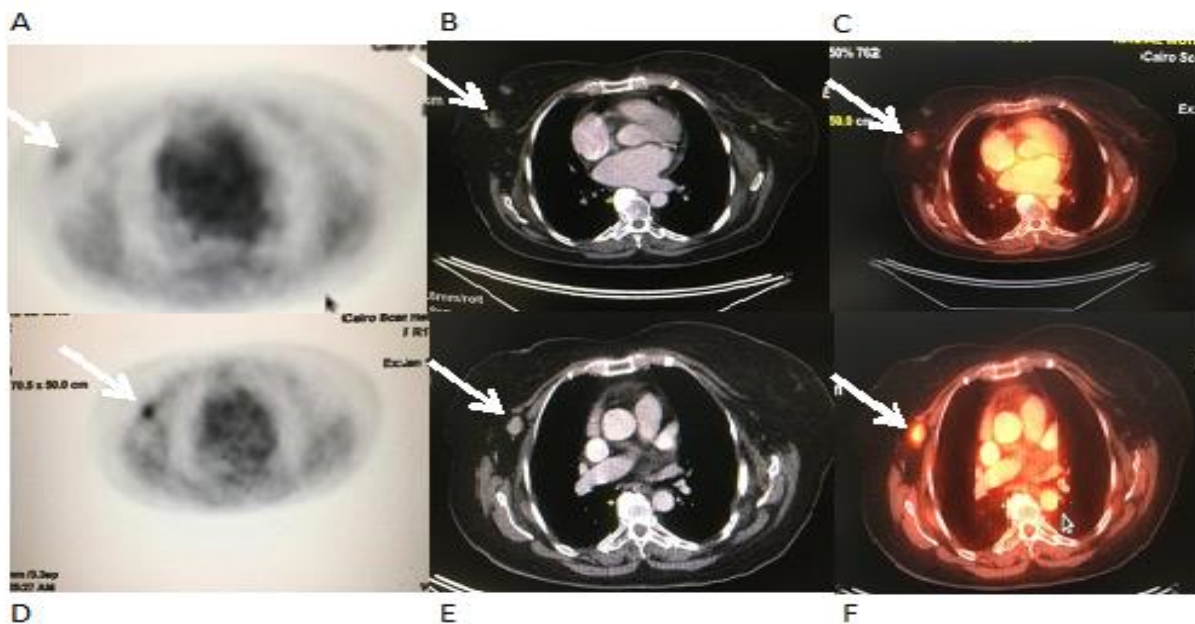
(A): Female patient who has got right breast cancer, small hyper metabolic soft tissue mass lesion is noticed at the right breast, it is indeterminate in CECT, while it showed increased FDG avidity supporting disease recurrence. (B) An equivocal pathologically enlarged right axillary nodal lesion on CECT (arrowed), I was avid for FDG with high SUV value, denoting metastatic nature.
